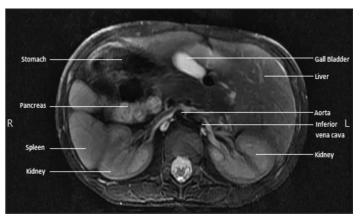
MRI abdomen showing evidence of situs inversus.
